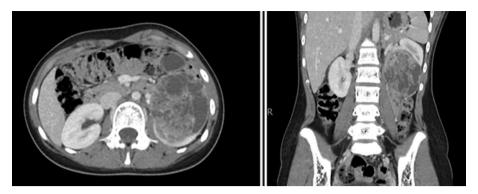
Surveillance CT imaging in 2017 revealing a large heterogeneous neoplastic lesion with areas of necrosis arising from the lower pole of left kidney. There was no lymphadenopathy or metastatic disease. This proved to be renal Ewing sarcoma/primitive neuroectodermal tumour on pathology.
